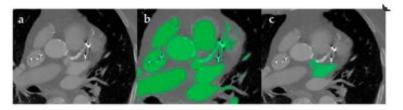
Dealing with Artifacts in Image Segmentation: (a) An axial contrast-enhanced CT scan of the heart displays conspicuous artifacts stemming from a metal implant and arterial calcification. (b) These artifacts undermine the efficiency of automatic segmentation through thresholding. (c) To isolate the region of interest, manual segmentation was utilized.
